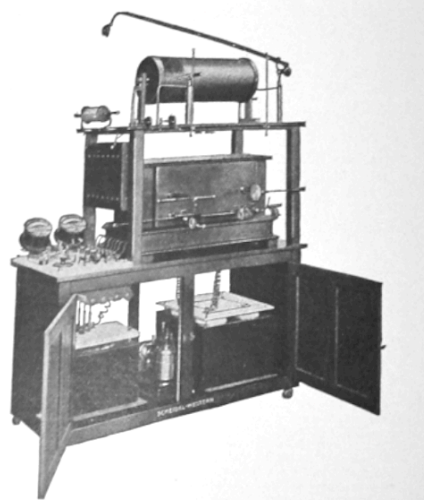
McIntosh Combination X-Ray and High Frequency Outfit (1911).²⁶³
